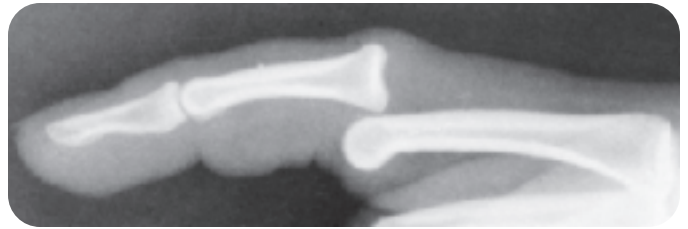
Radiography. Bone absorbs the x-rays and, therefore, appears white on the radiograph. This radiograph demonstrates a dorsal dislocation of the posterior interphalangeal joint.
